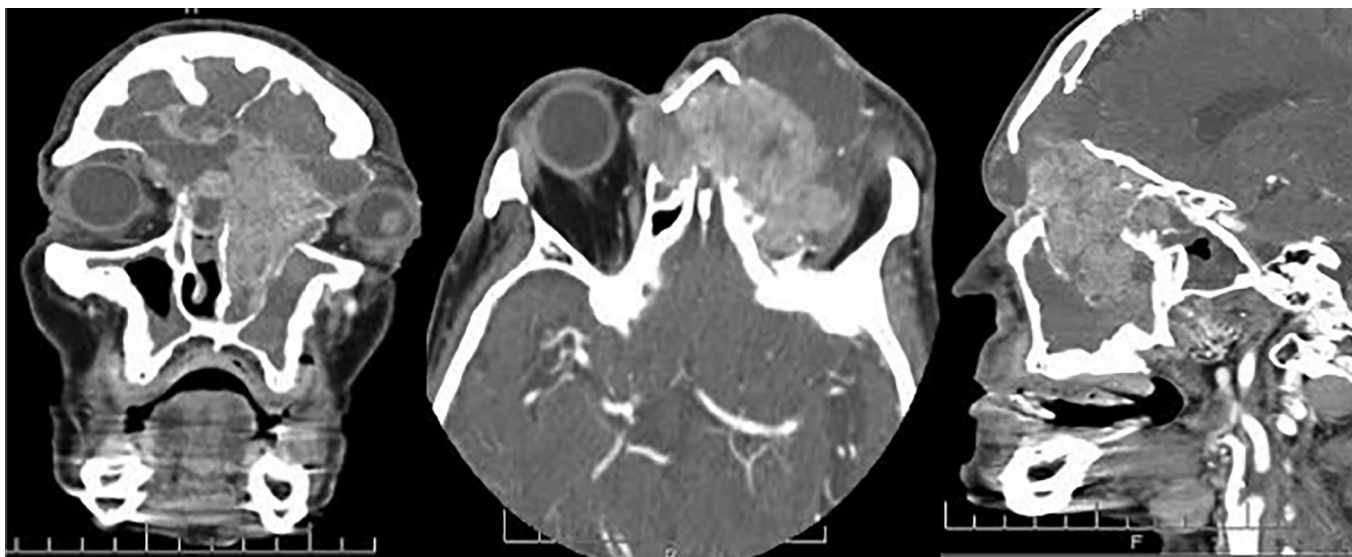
Pretreatment computed tomography of the sinuses demonstrates extensive disease filling the frontal and ethmoid sinuses, with mucocele formation, leading to left intraorbital extension and erosion of the posterior table of the frontal sinus.
